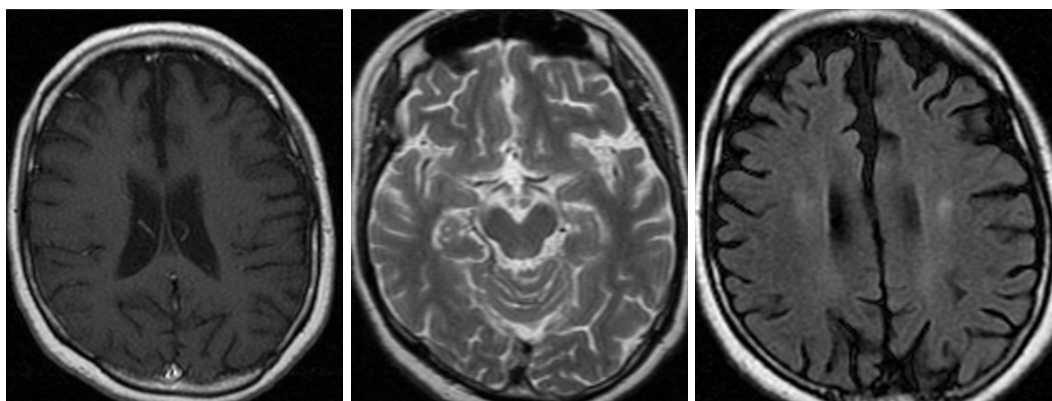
T1 brain magnetic resonance imaging (MRI) (left image), mild brain atrophy in T2 (middle image), and two hyperintense periventricular lesion in fluid-attenuated inversion recovery MRI (FLAIR) (right image)
